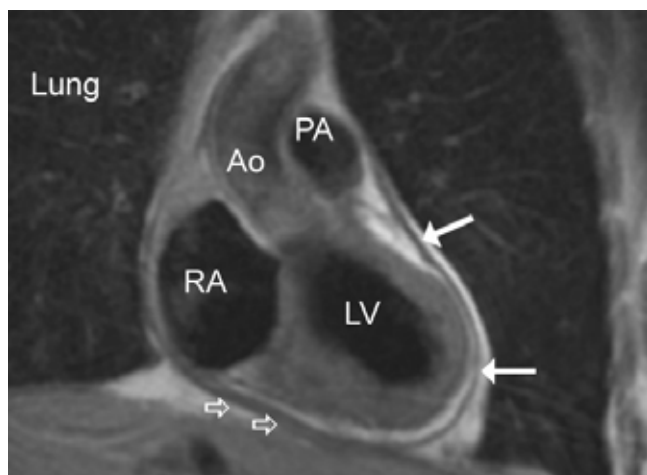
Coronal MRI through the left ventricular outflow tract showing normal (solid arrows) and thickened pericardium (open arrow), visible as the black layer in between bright layers of pericardial and epicardial fat.
